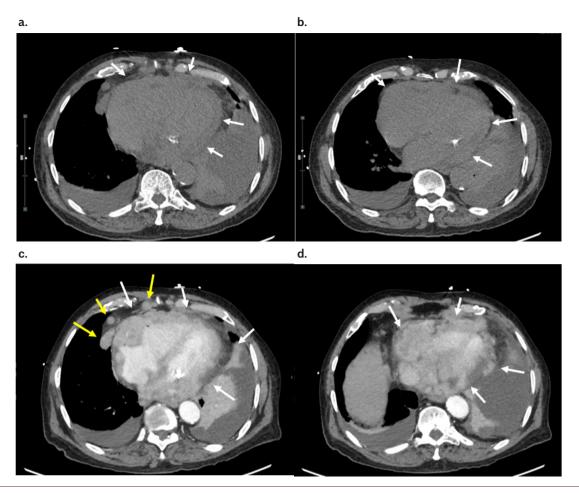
(a, b) Axial non-contrast CT images demonstrate a high-attenuation pericardial thickening (arrows), concerning for hemopericardium or pericardial infiltration, bilateral pleural effusion and left lower lobe compression atelectasis. (c, d) Axial post-contrast chest CT images show nodular, contrast-enhancing thickening of the pericardium (arrows), suggestive of malignant infiltration, enlarged pericardial lymph nodes (yellow arrows), consistent with lymphomatous involvement.
